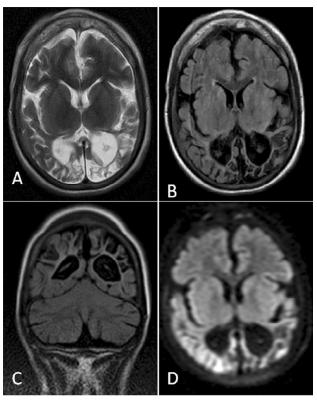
MR images of the 12-year-old female patient with cerebral palsy. Axial T2W (A), axial FLAIR (B), and coronal FLAIR (C) images show bilateral symmetrical areas of cystic encephalomalacia predominantly involving the occipital lobes, which show high signal on T2 and suppression on FLAIR weighted images. Bilateral symmetrical areas of gliosis are also seen in occipital and temporal. DWI (C) image shows no diffusion restriction. There is generalized cortical atrophy with ex-vacuo dilatation of the ventricular system.
